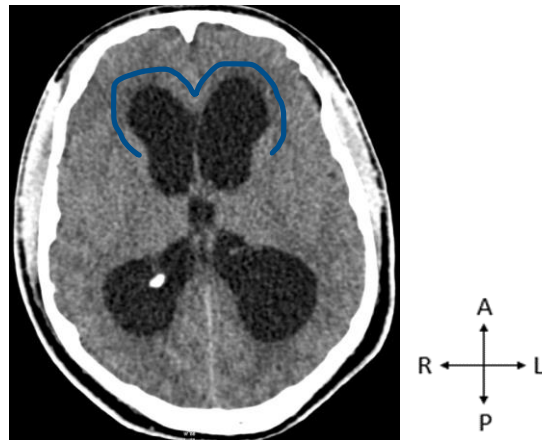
A CT scan of the brain in the axial view indicating the round frontal horn shape (blue). Image taken from the GSH PACS (20 October 2023). A - Anterior, R - Right, P - Posterior, L - Left.
